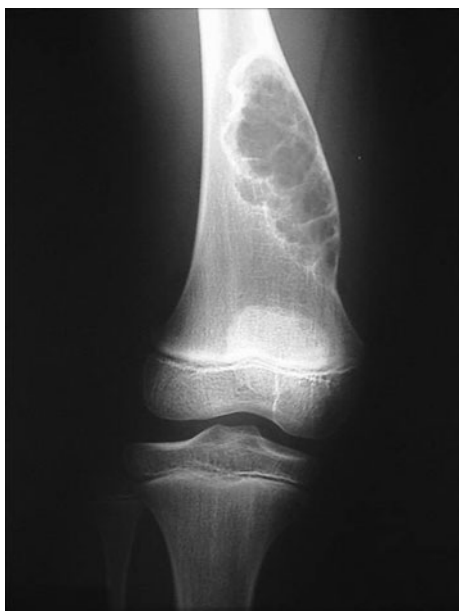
A 10.75-year-old girl presented with pain and swelling around her right knee lasting 3 months. Physical examination disclosed a hard painful mass in the distal part of the *right thigh*. Plain radiograph showed a radiolucent lesion in the metaphyseal part of the femur with a soap-bubble appearance. The lesion was expansile, the cortex was thinned and showed prominent marginal sclerosis
